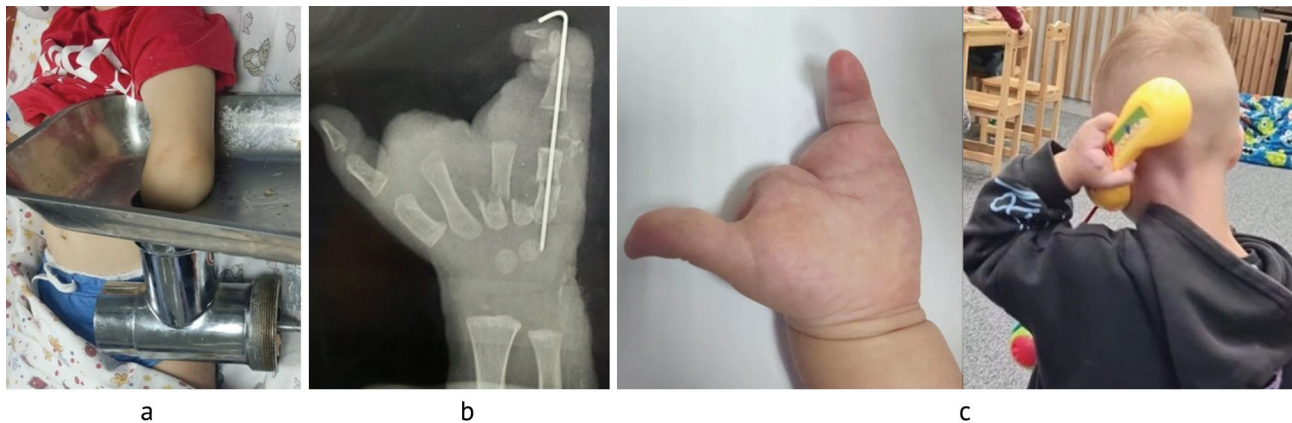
A crippling injury to the left upper limb in a 1.5-year-old child: *a* the child's left hand is in an electric meat grinder; *b* an X-ray of the left hand, direct view; *c* the child's left hand one year after the injury (authors' case, August 2022)
